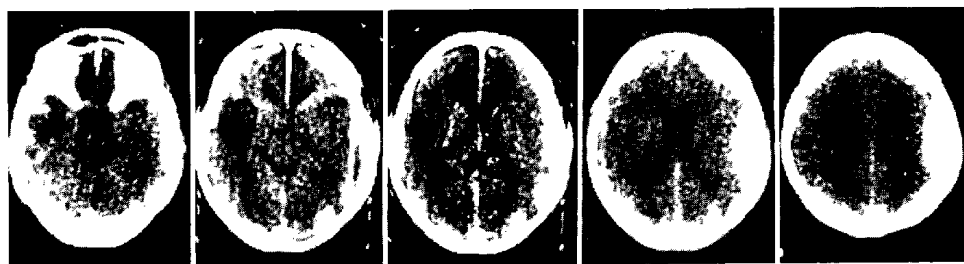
Epidural hematoma. 50-year-old male. CT was taken 7 days after trauma. A characteristic biconvex appearance in the fronto-temporal area on the right side and a low density contusion, probably due to contre-coup injury, in the left temporal lobe are shown.
